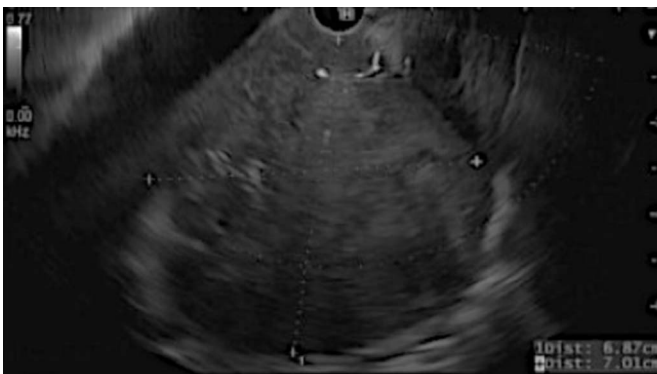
Endoscopic ultrasonography showing a mass in the posterior mediastinum, measuring 70×80 mm.
